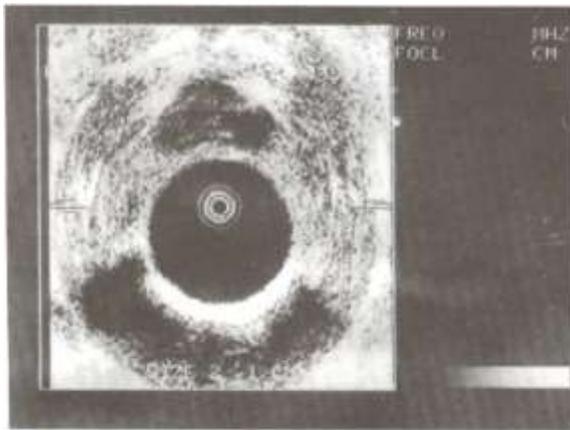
Transrectal axial sonogram showing small confined prostatic cancer. There is small hypoechoic area in the left posterior quadrant.
